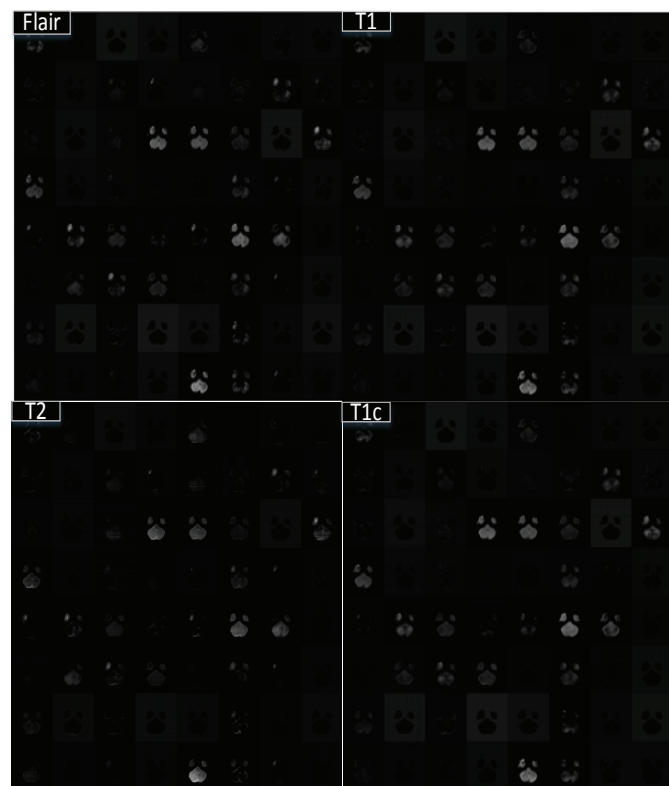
Feature maps from four MRI multimodalities.
